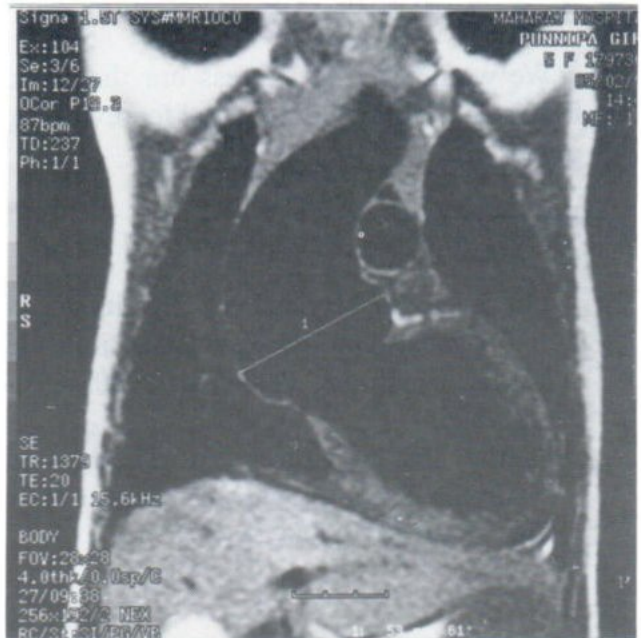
Coronal MR image shows a huge dilatation of the aortic root and the ascending thoracic aorta. Note the dilated left ventricle.
